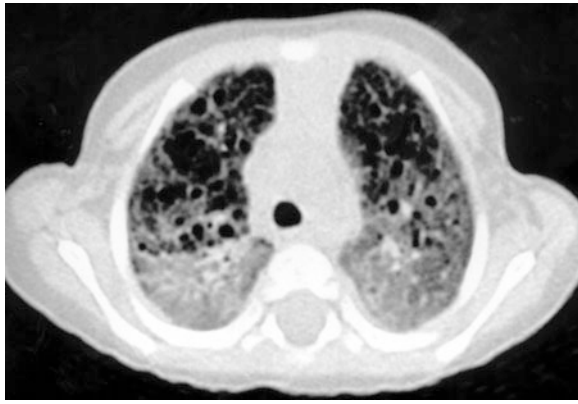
A 13-year-old boy with biopsy-proven idiopathic pulmonary fibrosis. HRCT shows ground-glass attenuation, intralobular lines, and air cysts and involving mostly the subpleural regions
